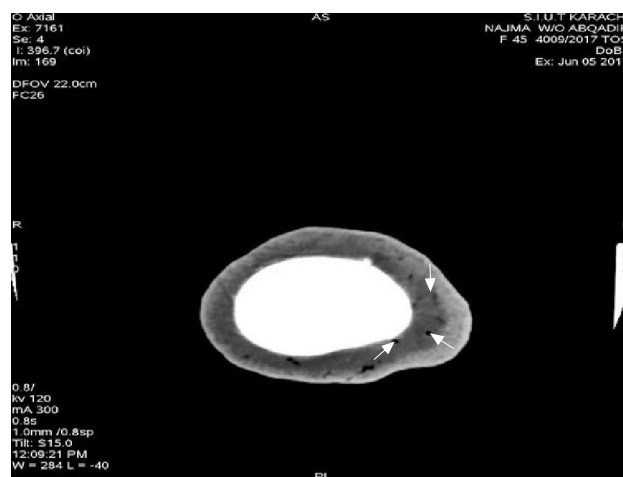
Non contrast CT brain shows multiple air bubbles in scalp veins
